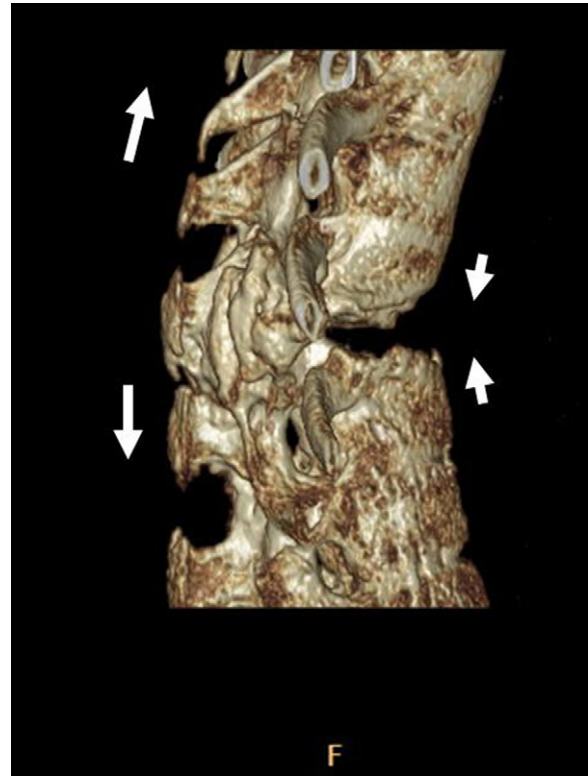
3D CT-scan, lateral view reconstruction. A 65-year-old male diabetic patient with spondylitis ankylopoietica, and under renal dialysis, sustained a T11–T12th thoracic spinal fracture after mild trauma, developing an atrophic non-union. When he was admitted to our Department, we considered that anterior flexion–posterior distraction forces could provoke complete spinal dissociation with subsequent paraplegia.
